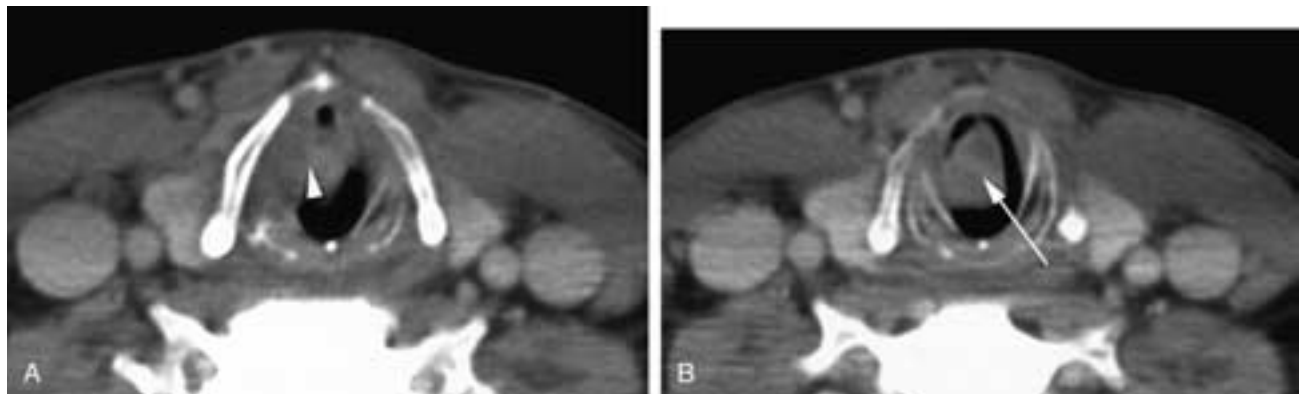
Kaposi's sarcoma. A, Axial CT to the level of the true cord (*arrowhead*). There is an exophytic lesion arising from the true cord and extending into the airway. B, The polypoid exophytic lesion (*arrow*) extended to the level of the cricoid. However, the tumor extension was exophytic into the lumen rather than extending along the mucosa.
